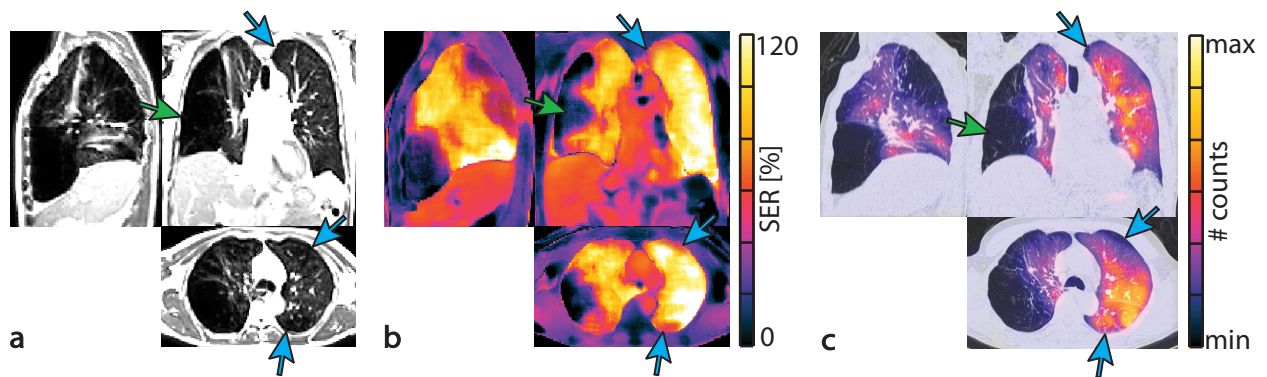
Side-by-side comparison of post-contrast ufSSFP (a), ufSSFP-SER (b), and $^{99\text{m}}\text{Tc}$ -MAA SPECT/CT fusion images (c) in a 61-year-old male patient with COPD GOLD II and emphysema. There is an extensive destruction of the right lung of this patient by emphysema with large confluent bullae (green arrows). Reduced SER is also seen in the emphysematous regions in the left lung (blue arrows) with apical predominance. Spatial coincidence is observed between areas of low SER in ufSSFP and areas of low radiotracer uptake in $^{99\text{m}}\text{Tc}$ -MAA SPECT. The whole lung SER was $75\% \pm 42\%$ (mean \pm SD).
